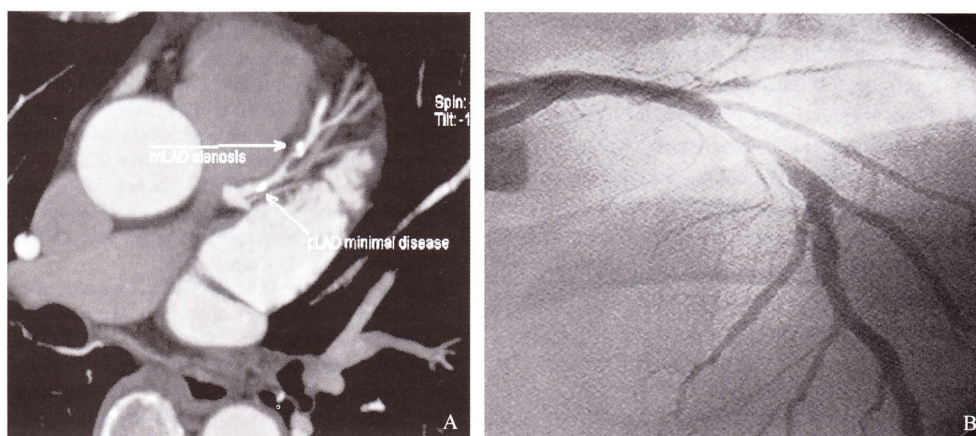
CTA of LAD (A) with significant stenoses in the mid-LAD. This was confirmed by CCA (B).
